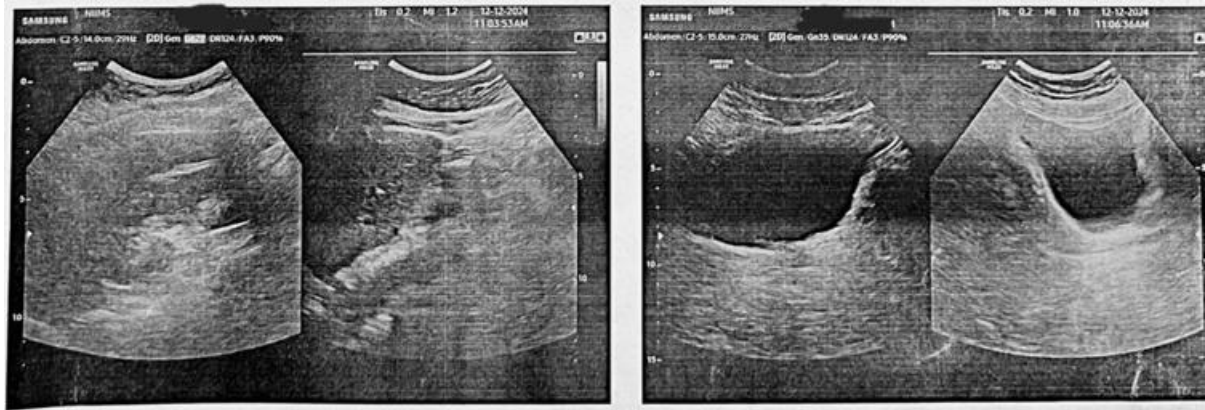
Ultrasound Whole Abdomen Report (The dotted area in the first image showing protruding content through hernial defect)
